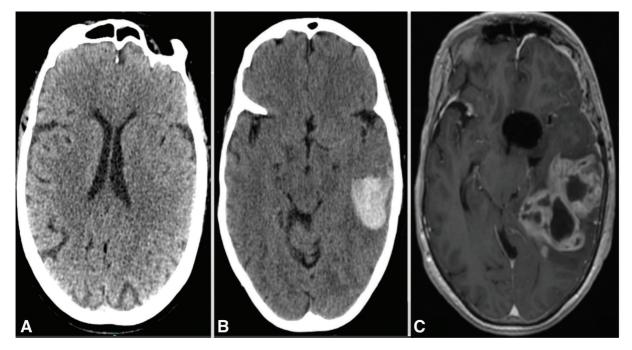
(A) Nonconstrast CT at presentation demonstrating subtle mass effect in the left temporal lobe, with little asymmetry of the lateral ventricles. (B) Nonconstrast CT at presentation demonstrating left temporal lobe hemorrhage. (C) MRI of the brain, axial view, T1-weighted, post-gadolinium, demonstrates a large lesion in the left frontotemporal region, with necrosis and typical ring-like enhancement suggestive of malignant brain tumor. The image also shows field distortion due to aneurysm clip.
